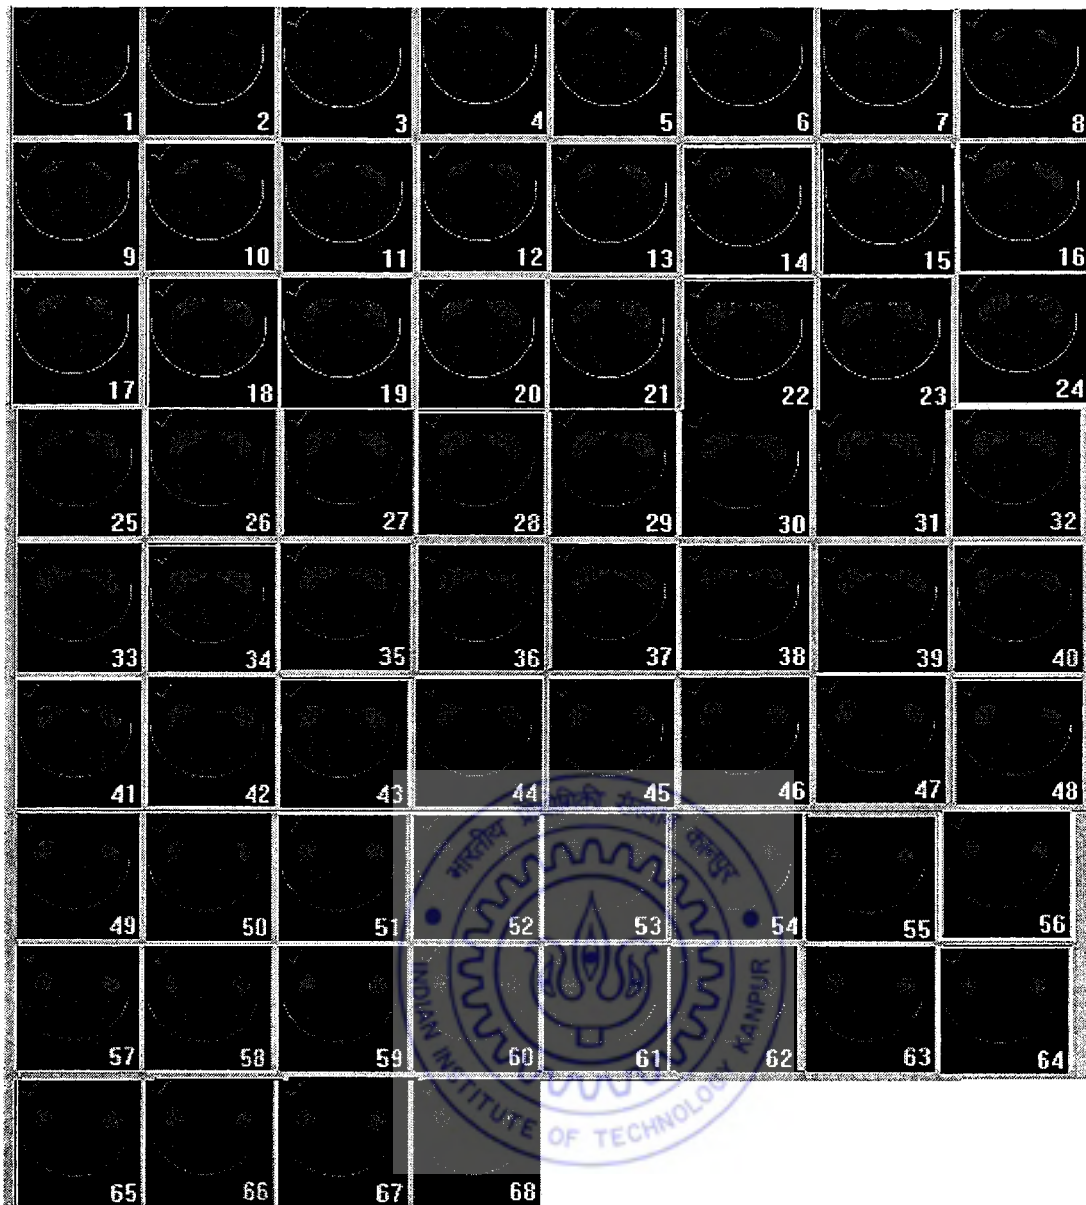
MRI scan data of clubfoot of Patient VI
